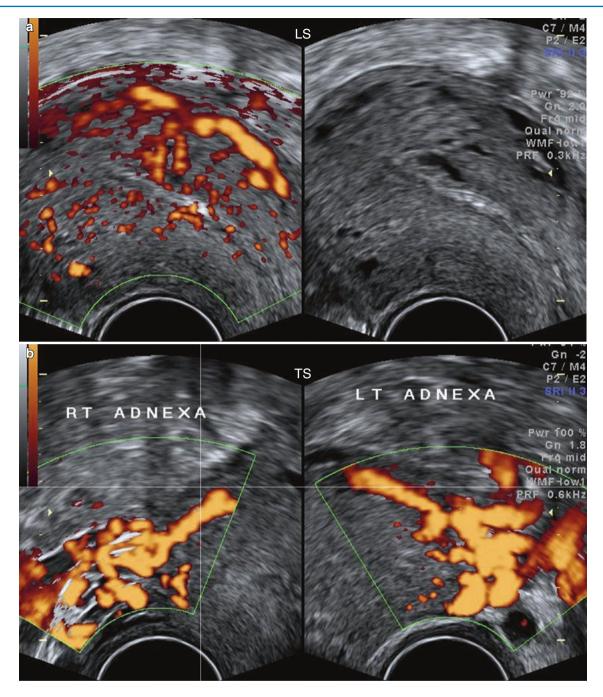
A small AV malformation in a patient whose last child birth with tubectomy was 25 years ago. (a) Shows a small lesion and prominent arcuate feeding vessels on Doppler. On greyscale the lesion is less well defined. (b) Prominent bilateral parametrial vessels are seen
